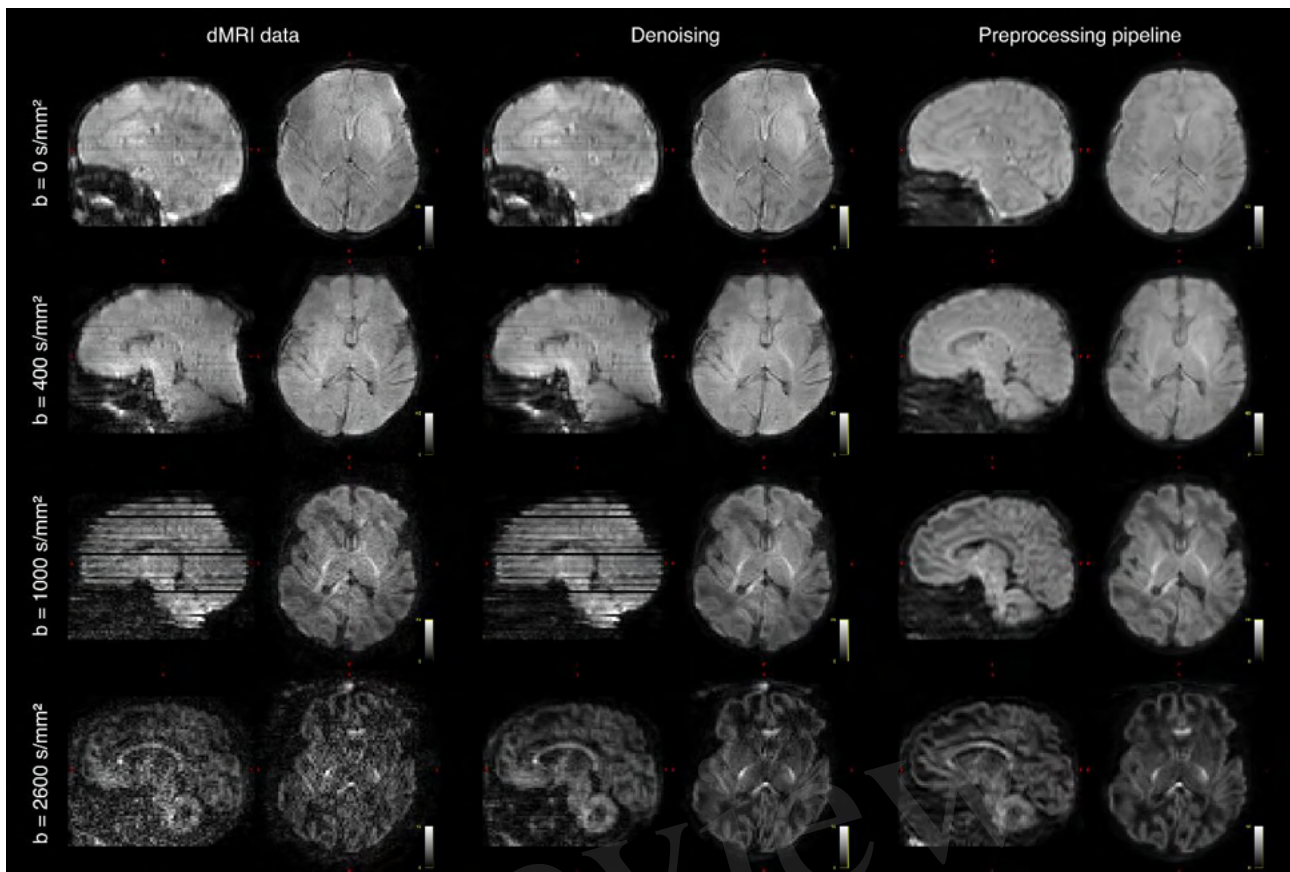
Diffusion MRI (dMRI) data from the same infant. Shown are 4 selected volumes with different b -values and phase encoding directions. Left: input data after MB-SENSE reconstruction. Middle: images after denoising. Right: images after motion and distortion correction and destriping.
